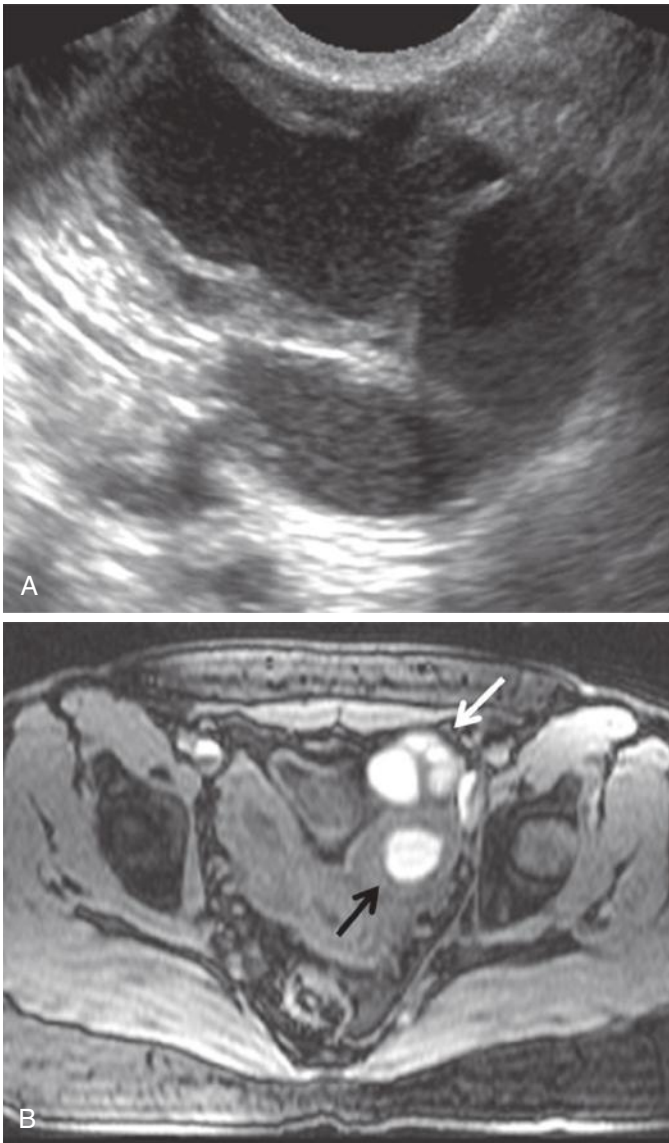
Endometriosis involving fallopian tube with hematosalpinx. A, Dilated fallopian tube with low-level intraluminal echoes compatible with blood. B, Axial fat-suppressed T1-weighted magnetic resonance image confirms high signal intensity in the tube (*white arrow*) compatible with hematosalpinx. The patient also has a unicornuate uterus with an obstructed left rudimentary horn containing blood (*black arrow*).
